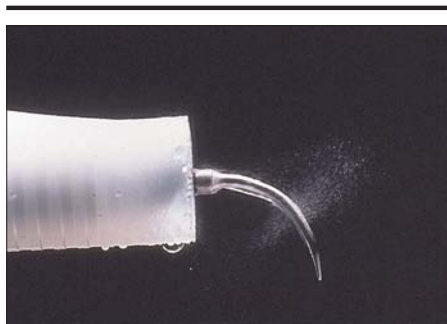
A large-bore high volume evacuator that attaches to the handle of an ultrasonic scaler. This device has been shown to reduce airborne contamination by more than 95 percent.
